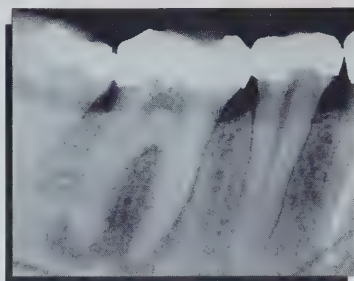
Mandibular first molar with large periapical radiolucency requiring root canal therapy.
